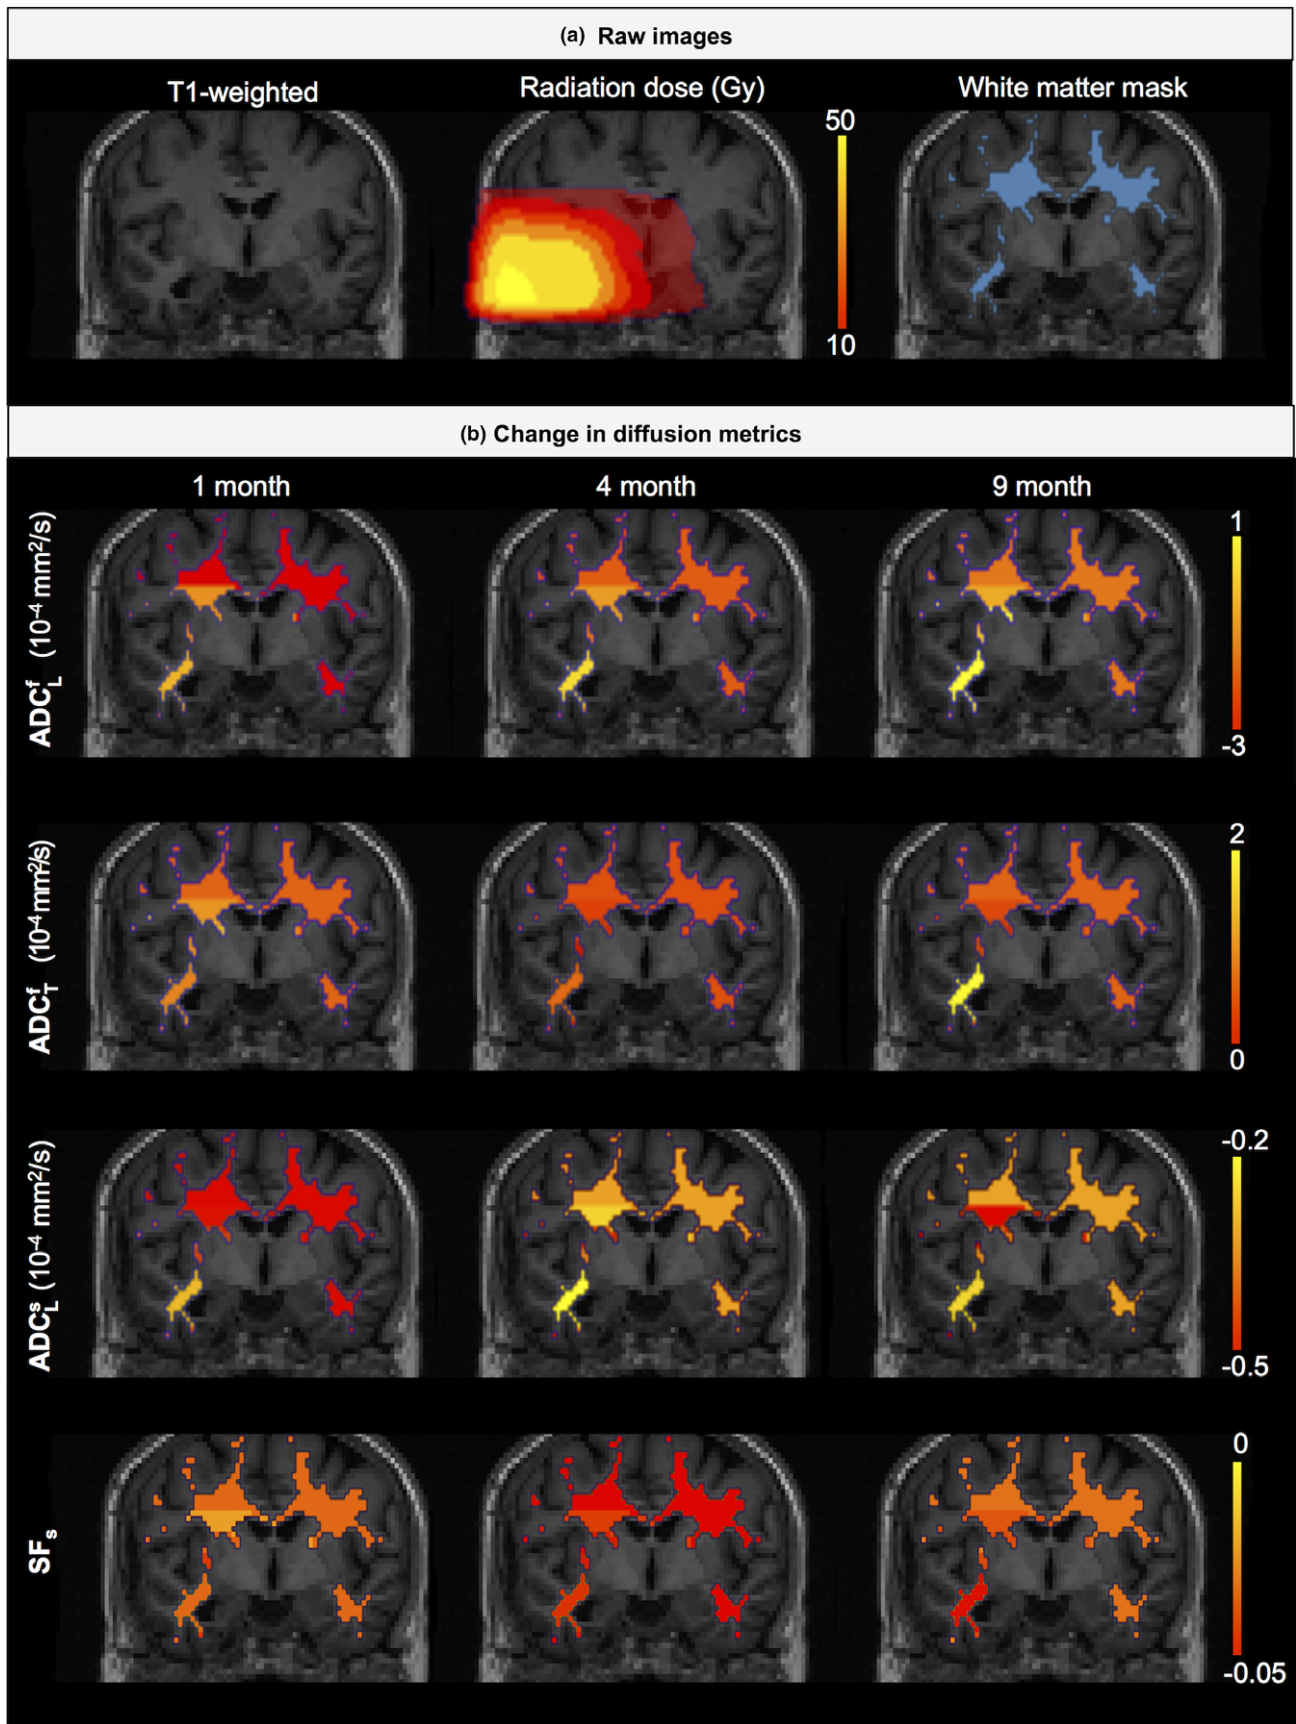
Example of T1-weighted, radiation dose distribution, white matter mask, and maps of changes in diffusion metrics in a patient. [Color figure can be viewed at [wileyonlinelibrary.com](http://wileyonlinelibrary.com)]
